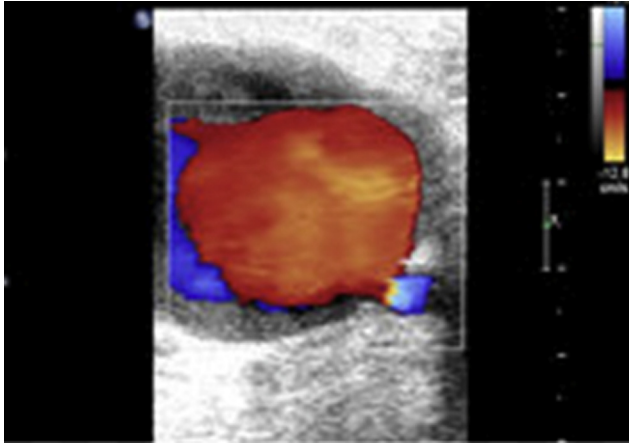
Color Doppler image showing swirling flow in the pseudoaneurysm cavity.
